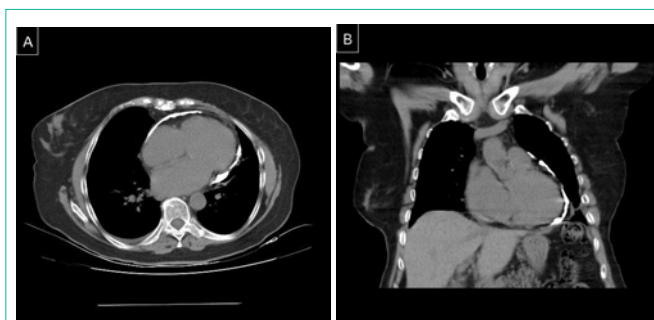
Extensive calcification of the pericardium showed by computed tomography: axial (A) and coronal (B) views.
